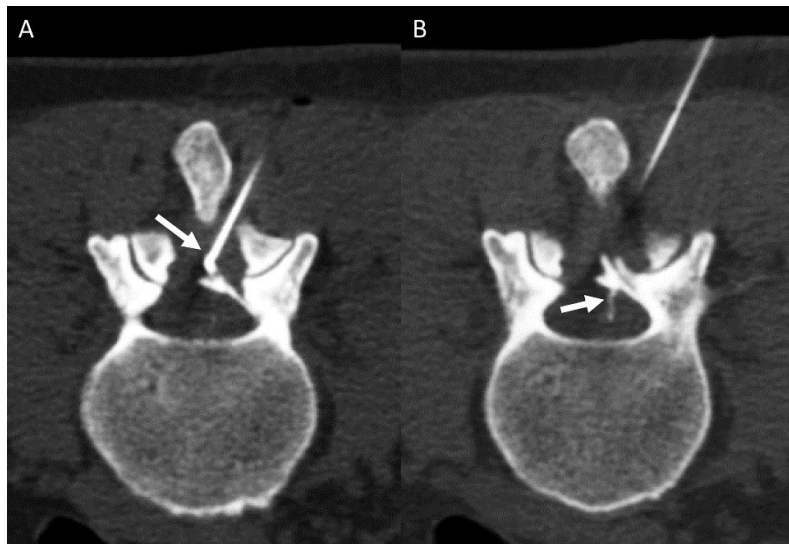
CT fluoroscopy images from the injection of contrast into the epidural space at L3-L4 show the needle tip in the dorsal aspect of the dorsal epidural space (A, arrow), and the jet of contrast (B, arrow) from the epidural space through a dural defect into the subarachnoid space.
